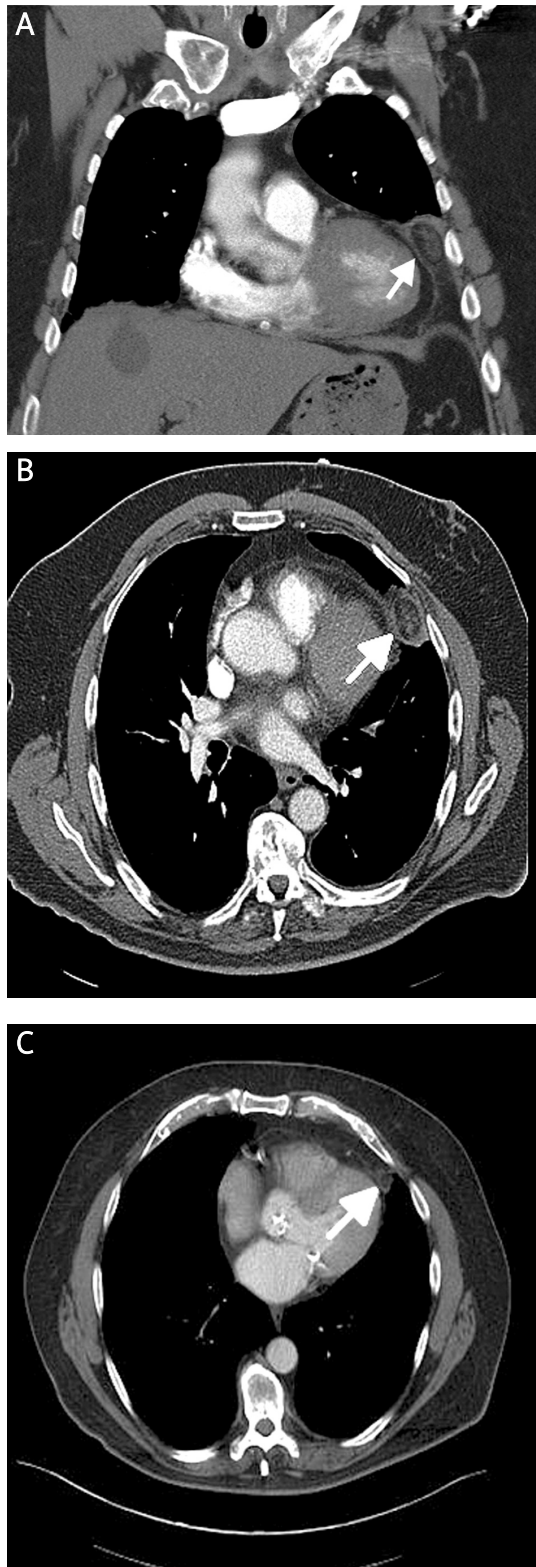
Chest CT: A) Coronal section shows low attenuation of the pericardial fat (arrow). An area of pathologic fat necrosis and inflammation is seen lateral to the pericardial fat, corresponding to the shadow seen on admission CXR. An axial section (B), shows the necrotic area (arrow). Six months later (C), the lesion measured 1.4 cm
